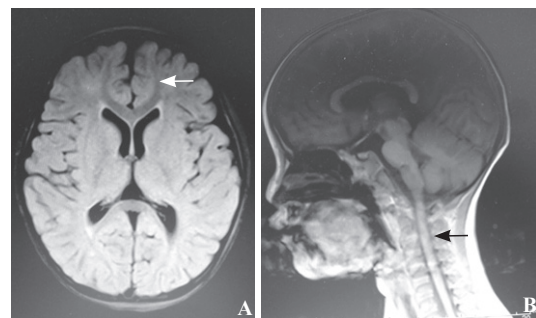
Cranial (A) and spinal (B) MRI showing multiple abnormal patchy signals within the white matter of both cerebral hemispheres and a possible cervical spinal cord contusion.
